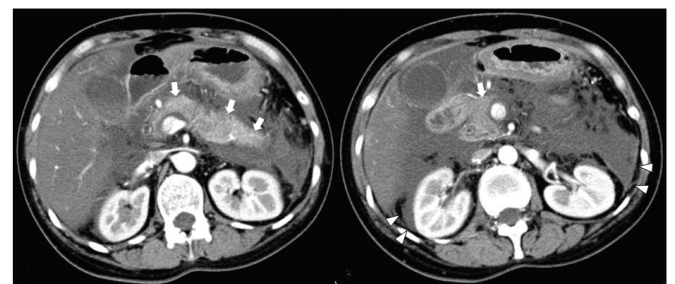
CT imaging of abdomen (Case 1)
